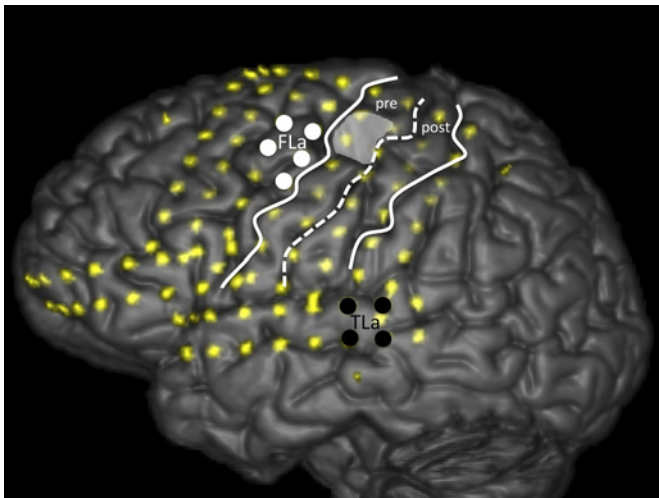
3D MRI surface rendering that shows the positions of subdurally implanted electrodes (vague yellow dots) of a 27-year-old patient with refractory epilepsy due to a ganglioglioma in the left precentral gyrus (shaded grey area). The precentral gyrus (pre) and postcentral gyrus (post) and central sulcus (dashed white line) are marked. Electrocortical stimulation is carried out while the patient performed language tasks. Electrical stimuli consisted of trains (7 s duration) of monophasic pulses (50 Hz, pulse width 0.2 msec, 6 mA). Reproducible errors were induced by electrocortical stimulation of adjacent electrodes during picture naming and reading aloud in two discrete areas. A frontal language area (FLa) was identified by stimulating electrodes on the posterior part of the medial frontal gyrus (white solid dots). A temporal language area (TLa) was identified by stimulating electrodes on the posterior part of the superior temporal gyrus (black solid dots). Language errors were not due to impairment of motor (mouth/tongue) function or after discharges. No errors occurred on similar tasks when stimulating electrodes in the lateral inferior frontal area where Broca's area would traditionally be expected. In this case, the FLa (Broca) appears to be shifted cranially while the localisation of the TLa (Wernicke) is unaltered.
